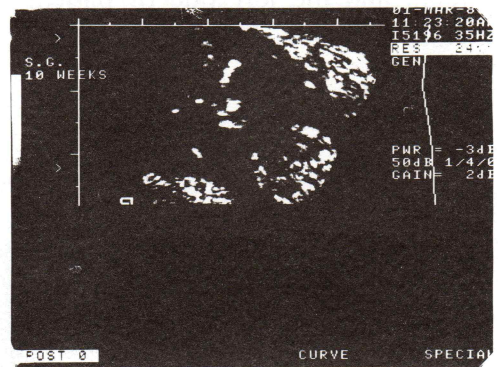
Transvaginal sonography shows a clear picture of both arms at 10 weeks gestation.
